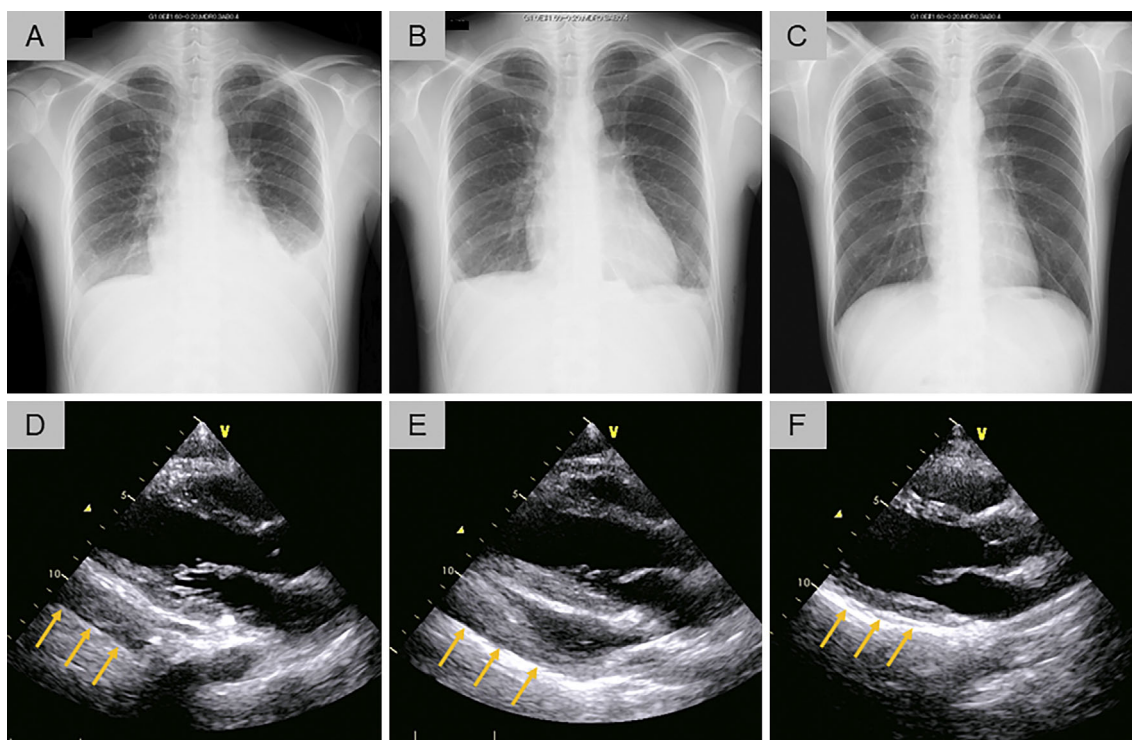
Chest X-rays and cardiac ultrasonography. (A) and (D) (On admission). Chest X-rays showed an enlarged cardiac silhouette and marked bilateral pleural effusion (A), and cardiac ultrasonography showed mild pericardial effusion (indicated by arrows) (D). (B) and (E) (after the first steroid pulse and before the addition of cyclosporine A). A chest X-ray showed the further enlargement of the cardiac silhouette and a decrease of bilateral pleural effusion in comparison to the chest X-ray that was obtained on admission (B). Cardiac ultrasonography showed an increase in pericardial effusion and mild thickening, and the epicardium showed high intensity (indicated by arrows), corresponding to constrictive pericarditis (CP) (E). (C) and (F) After the second injection of tocilizumab (TCZ). Chest X-rays (C) and cardiac ultrasonography (F) showed the improvement of the pleural and pericardial effusion (indicated by arrows).
